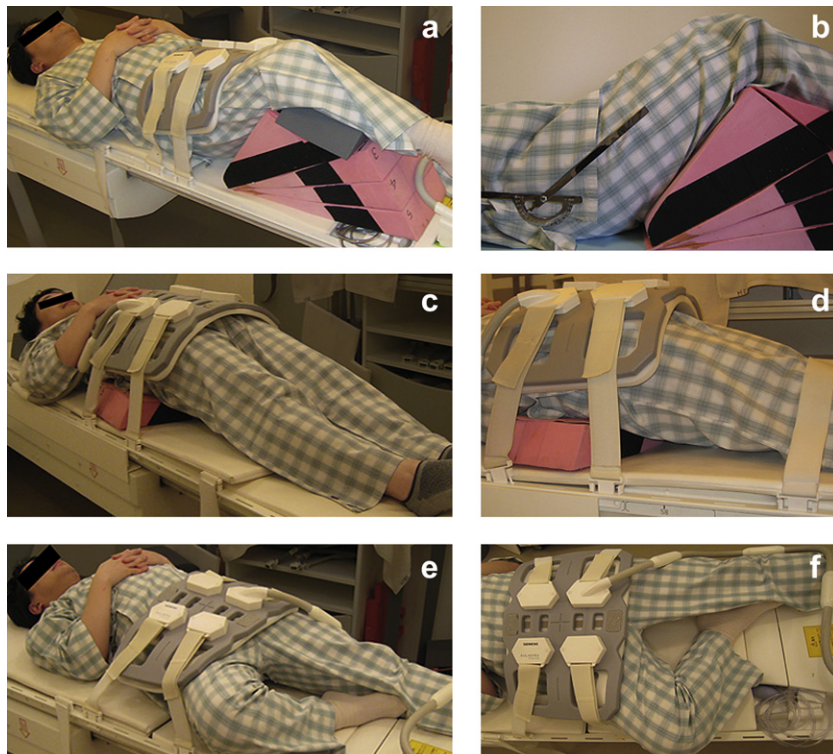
Data acquisition of MRI using a non-magnetic movable device made from non-ferromagnetic materials. (a), (b) 45° flexion; (c), (d) 15° extension; (e), (f) The Patrick position.
